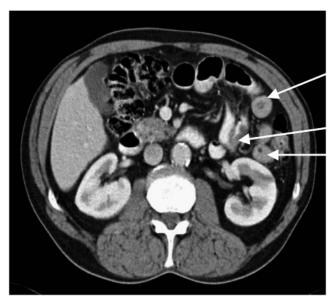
Axial abdominal CT image showing thickened small-bowel segments (arrows) in patient with EATL.
